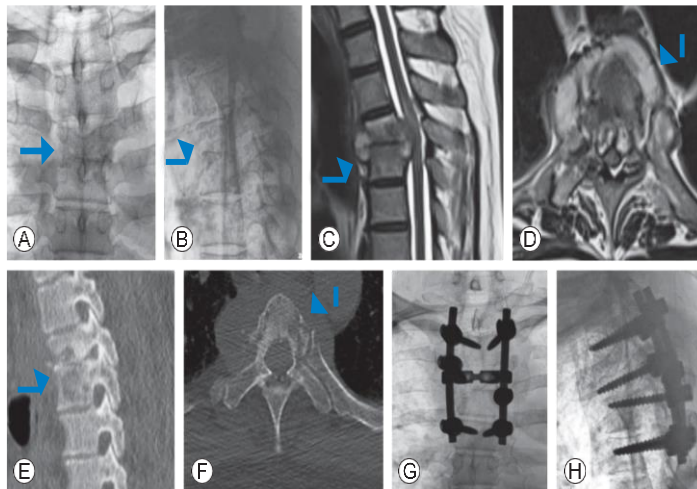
X-rays (A, B), MRI (C, D), CT (E, F), and X-rays (G, H) of a patient before and after posterior stabilization and transpedicular decompression through pediclectomy with anterior reconstruction utilizing a polyether ether- ketone
